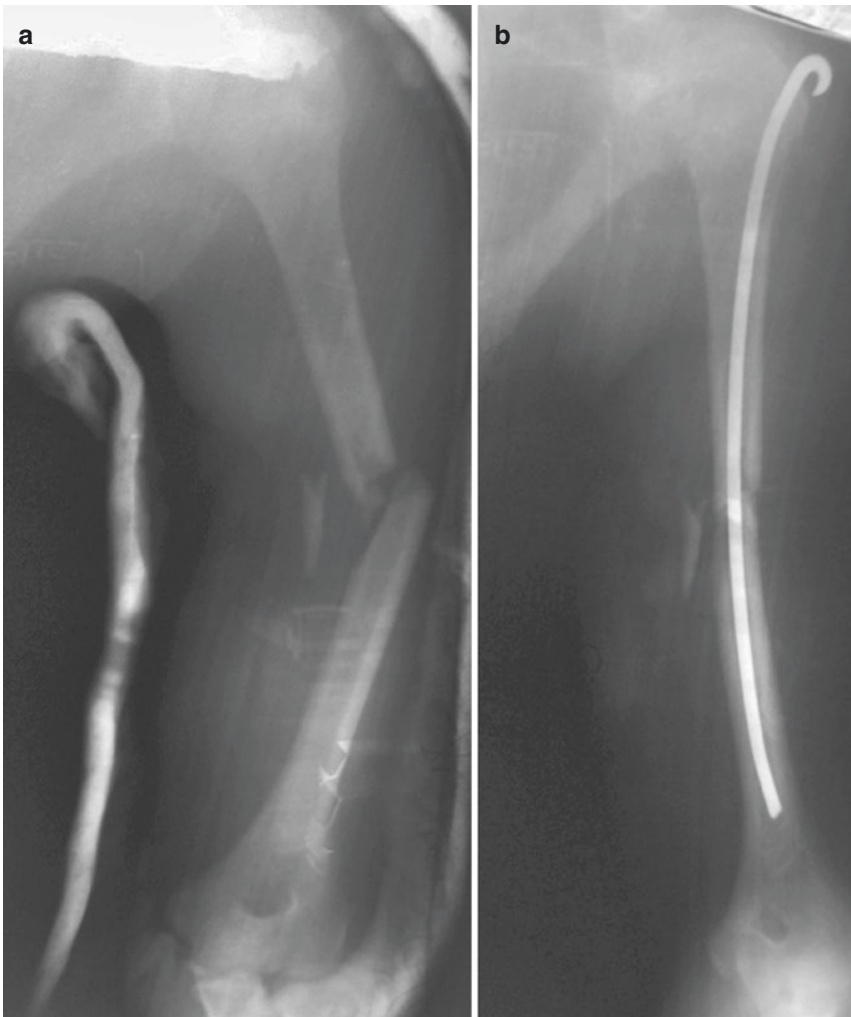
Rush rod fixation of a mid-shaft humerus fracture in which the angulation could not be controlled with a coaptation splint. (a) Persistent angulation in the splint. (b) Postoperative X-ray after Rush rodding
